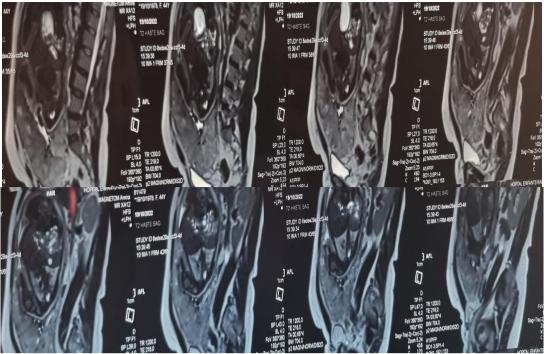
Pelvic MRI showing placenta accreta previa.
